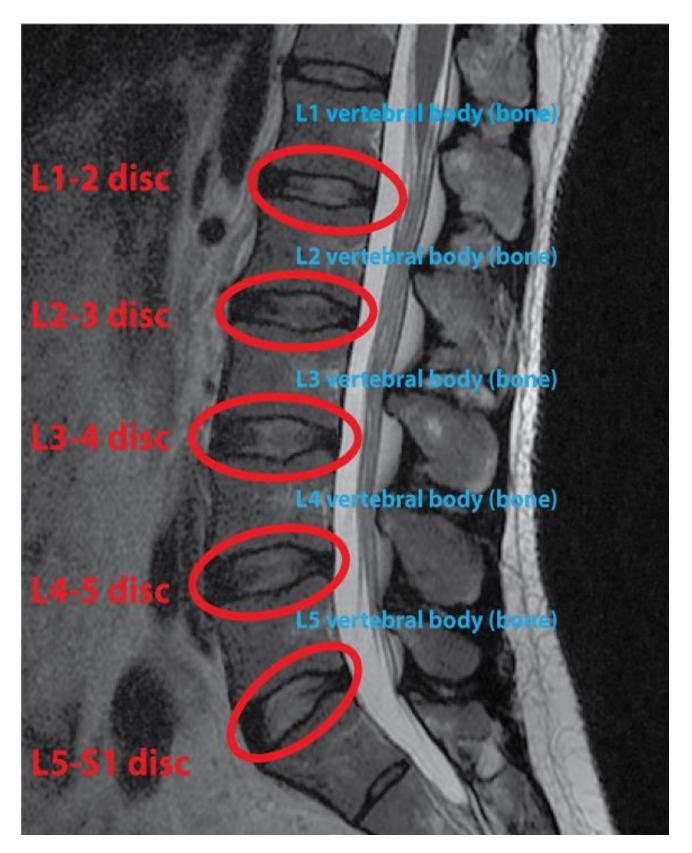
MRI showing intervertebral discs
